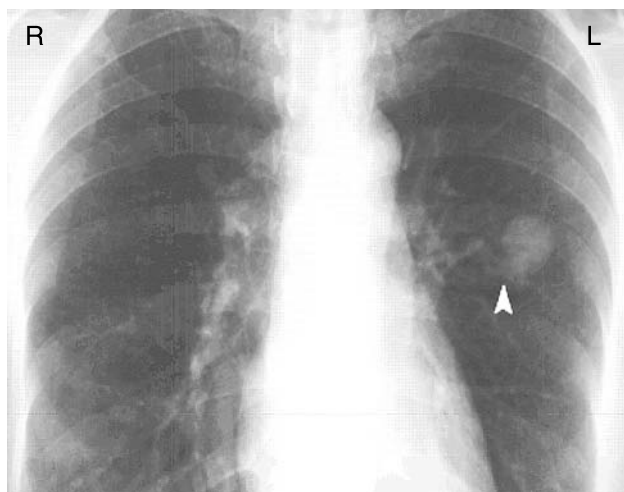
Conventional chest X-ray showing a nodular lesion (arrow) in the upper lobe of the left lung.
